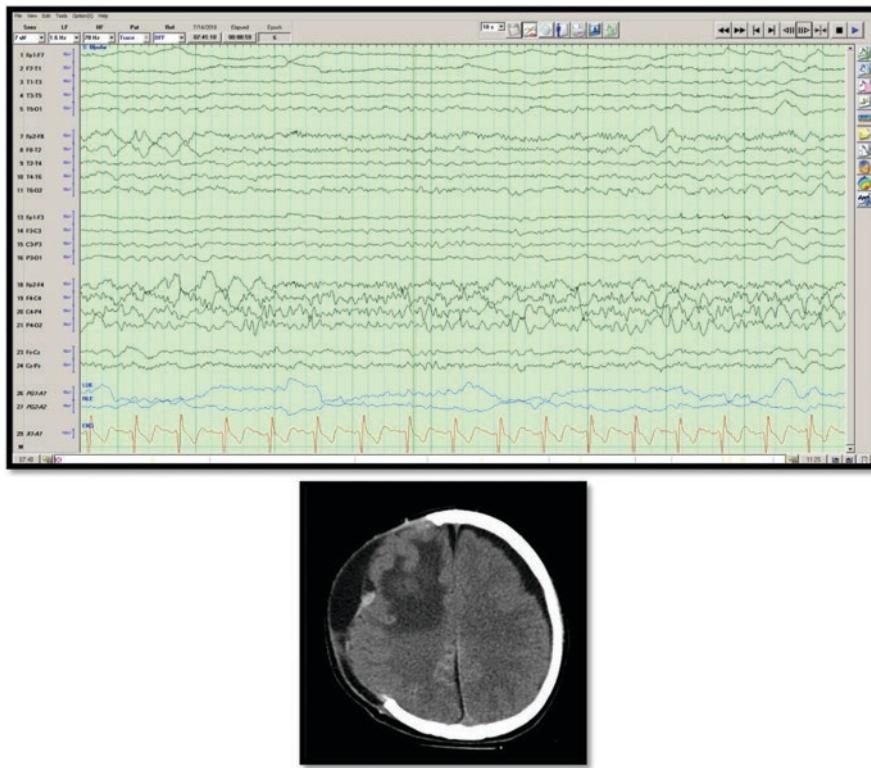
Breach rhythm in the right hemisphere (top EEG tracing), maximal right fronto-centro-parietal region in a 21-year-old man with right frontal hematoma status post evacuation and hemi-craniectomy to relieve cerebral edema. Note higher amplitude and sharply contoured beta activity. There is intermixed delta/theta slowing secondary to traumatic injury. Below the EEG tracing is his CT head image showing the skull defect and right cerebral edema and encephalomalacia
